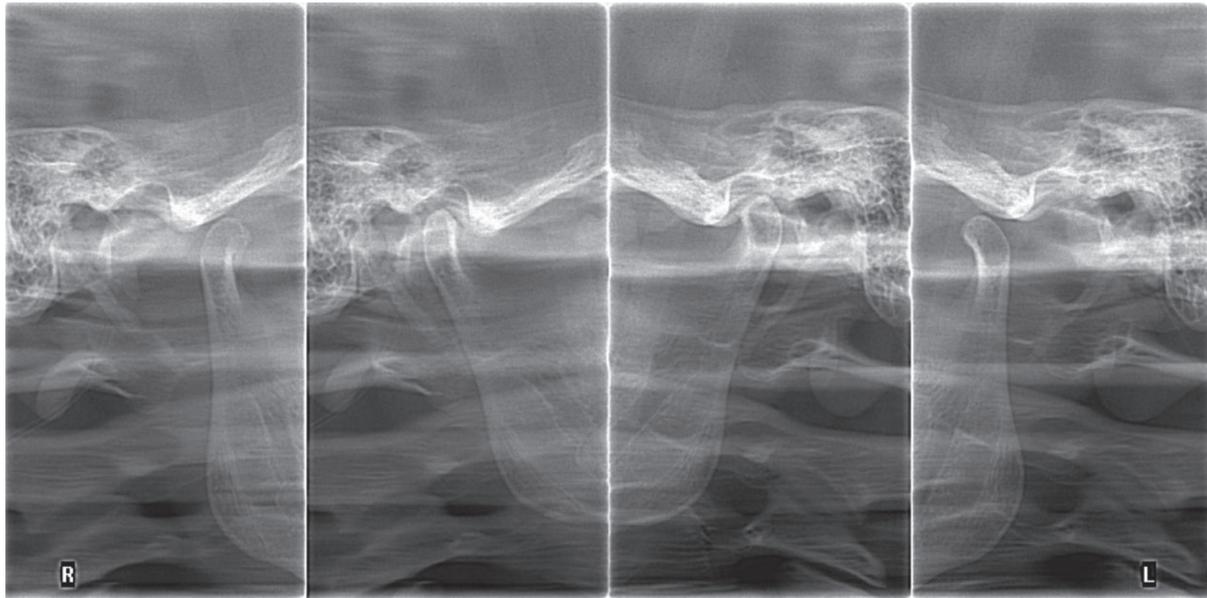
The radiographs of the TMJ with nonconcentric condylar position: an excessive left-sided occlusal vertical dimension (inferior condylar position in occlusion—internal scan, left TMJ).
